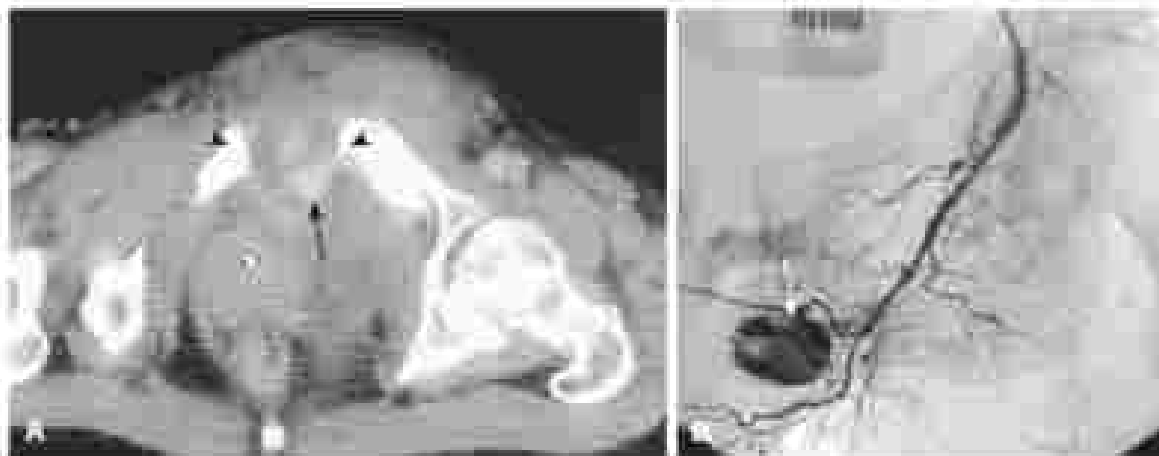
“Open book” pelvic fracture with arterial bleeding treated with orthopedic stabilization and embolization. (A) Axial CTA demonstrating the fracture of the pubic symphysis (arrowhead) and extravasation (arrow) of contrast into a pelvic hematoma. (B) Selective left internal pudendal artery angiogram demonstrating extravasation (arrow). The bleeding was subsequently embolized (arrow) (A and B) with Vascular and Interventional Radiology (for Arthroscopy, Philadelphia: Lippincott Williams, 2004).
